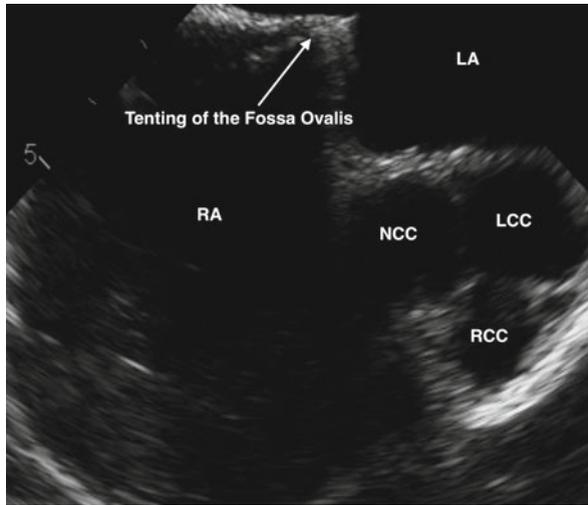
Transesophageal imaging showing tenting of the Fossa Ovalis during trans-septal access. The right atrium (RA) and left atrium (LA) are seen as well as the non coronary cusp (NCC), left coronary cusp (LCC) and right coronary cusp (RCC) of the aortic valve
